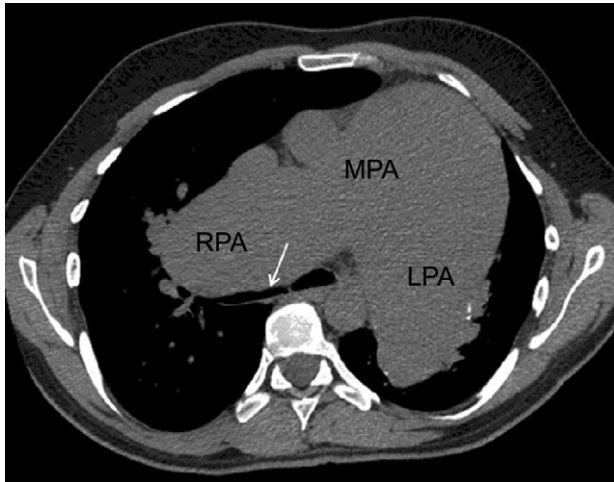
Preoperative chest computed tomography image. The arrow depicts extrinsic compression of the right main stem bronchus. (LPA = left pulmonary artery; MPA = main pulmonary artery; RPA = right pulmonary artery.)
